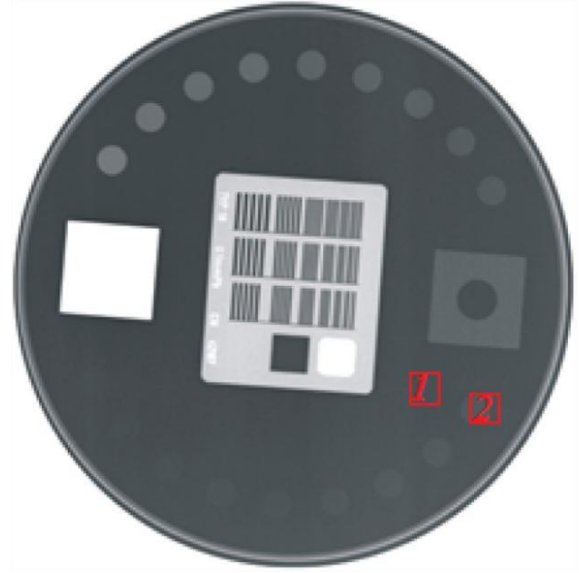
TOR18 FG X-ray [6].
